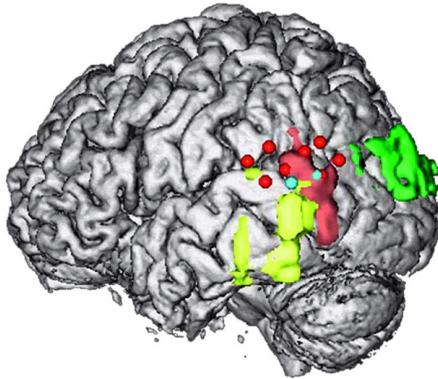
Results of a mean lesion overlap analysis of MRI scans in five patients with OBEs or related experiences. The analysis centers on the temporo-parietal junction. Blue points show the locus of electrical cortical stimulation artificially inducing OBE-like phenomenal states. Colored areas are activated during epileptic seizures. Reproduced with permission from Blanke *et al.* (2004).
